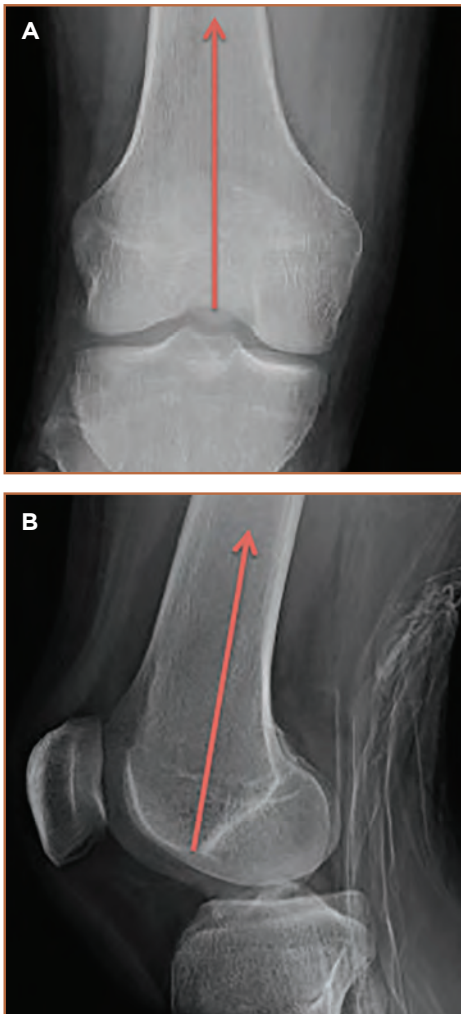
A) Anteroposterior and B) lateral radiographs femoral shaft fractures treated with retrograde nailing, showing recommended entry point and trajectory of guide pin (red arrow).
